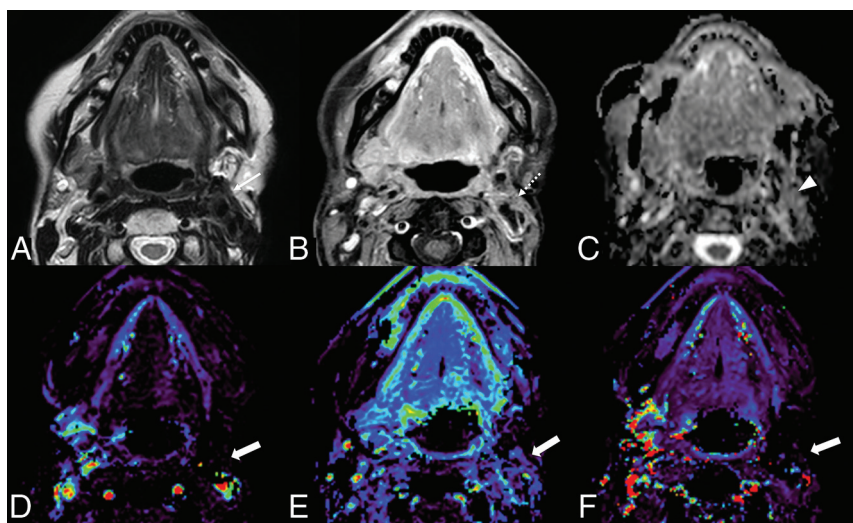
Benign posttreatment change of head and neck cancer in a 64-year-old woman after surgery and radiation therapy for mucoepidermoid carcinoma of the left parotid gland. The left parotid surgical bed shows low signal intensity (arrow) on T2WI (A) and mild enhancement (dotted arrow) on postcontrast fat-suppressed T1WI (B). The ADC map (C) shows no prominent low signal (arrowhead), with an $nADC_{mean}$ of 1.75. DCE-MR imaging (D, Vp ; E, Ve ; F, K^{trans}) shows no increased parameters (thick arrows) with an nVp of 0.33, nVe of 0.33, and nK^{trans} of 0.03.
